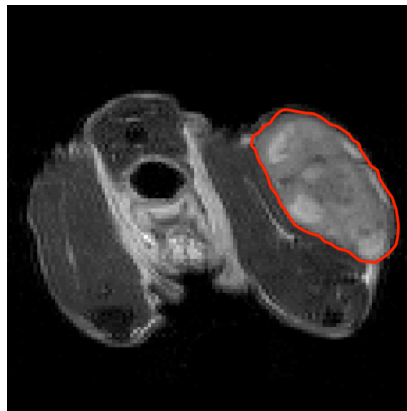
Representative example of a T_2 -weighted magnetic resonance image displayed with tumor boundaries highlighted in red. Note the sufficient contrast between tumor and muscle for accurate delineation of tumor boundaries.
